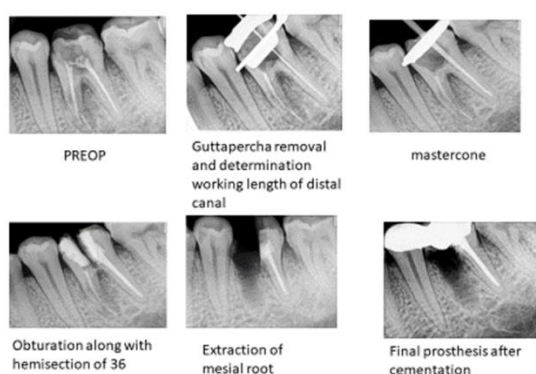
Radiographs of case 2.
